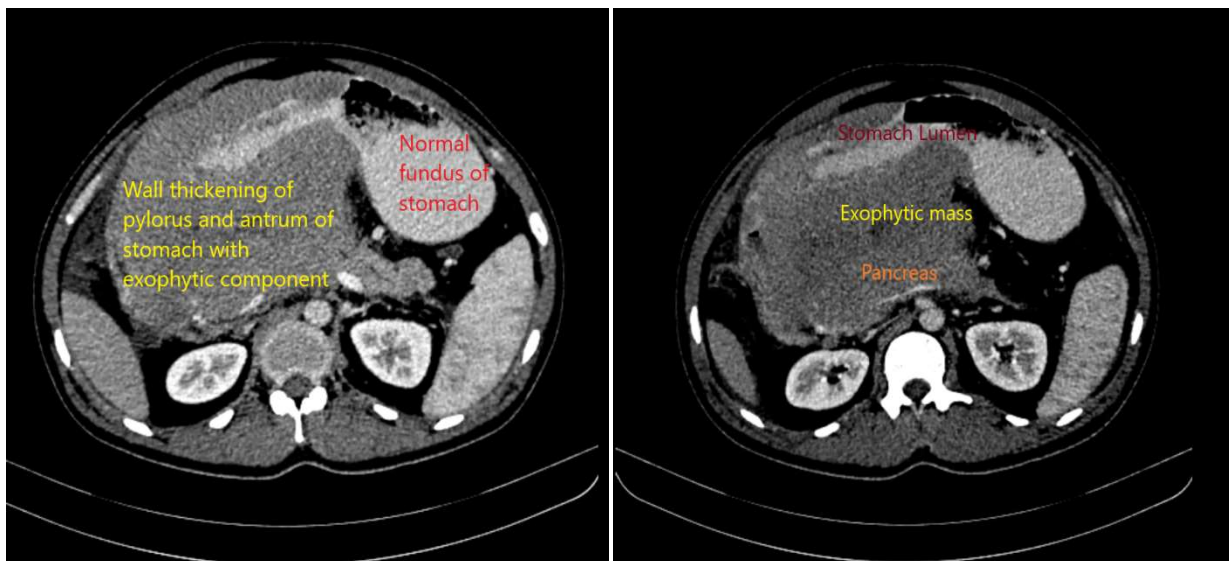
Post-contrast CT axial and coronal Image showing circumferential slightly irregular wall thickening of stomach with large exophytic component, loss of fat plane can be seen with head and body of pancreas. Fundus of stomach and tail of pancreas is normal
